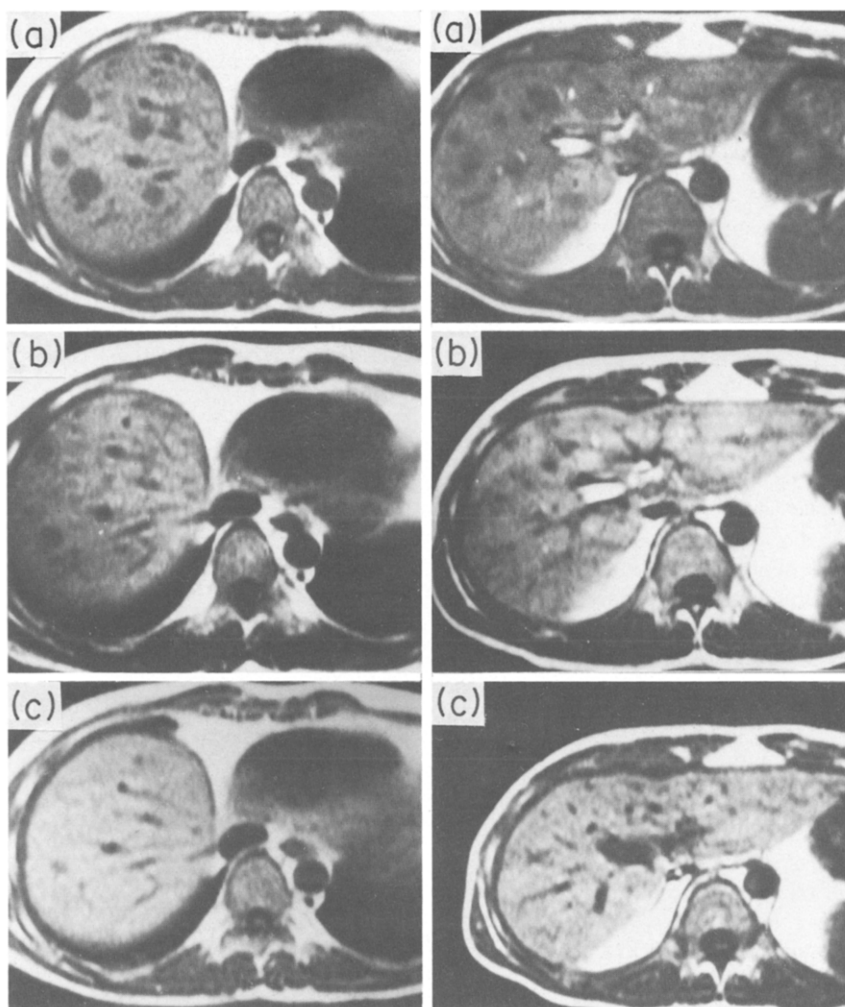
MRI of liver lesions at the start of therapy (a), following 5-FU and leucovorin (b) and following rIL-2 (c). Significant regression is seen after each phase of therapy.
